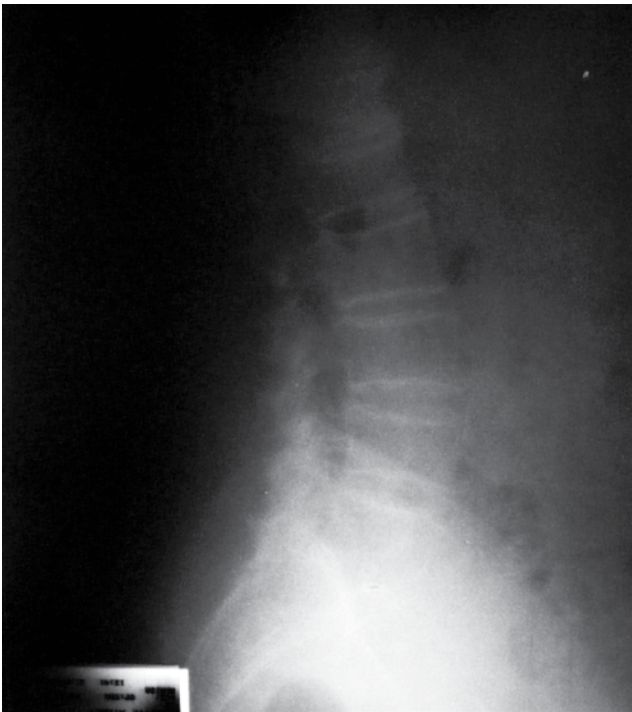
Lateral radiograph of the lumbar spine
